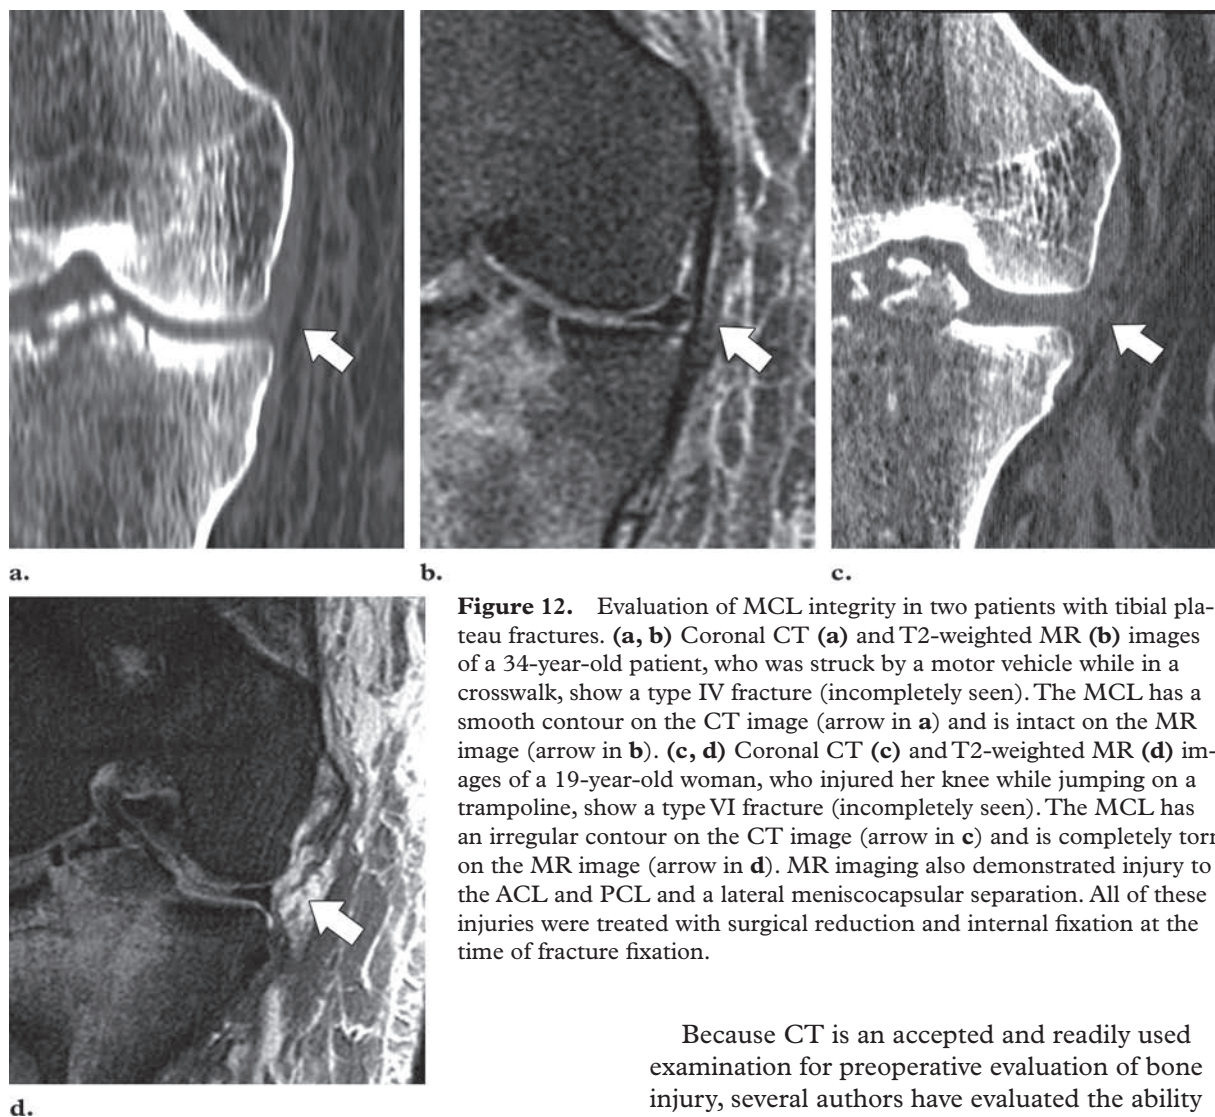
Evaluation of MCL integrity in two patients with tibial plateau fractures. (a, b) Coronal CT (a) and T2-weighted MR (b) images of a 34-year-old patient, who was struck by a motor vehicle while in a crosswalk, show a type IV fracture (incompletely seen). The MCL has a smooth contour on the CT image (arrow in a) and is intact on the MR image (arrow in b). (c, d) Coronal CT (c) and T2-weighted MR (d) images of a 19-year-old woman, who injured her knee while jumping on a trampoline, show a type VI fracture (incompletely seen). The MCL has an irregular contour on the CT image (arrow in c) and is completely torn on the MR image (arrow in d). MR imaging also demonstrated injury to the ACL and PCL and a lateral meniscocapsular separation. All of these injuries were treated with surgical reduction and internal fixation at the time of fracture fixation.
